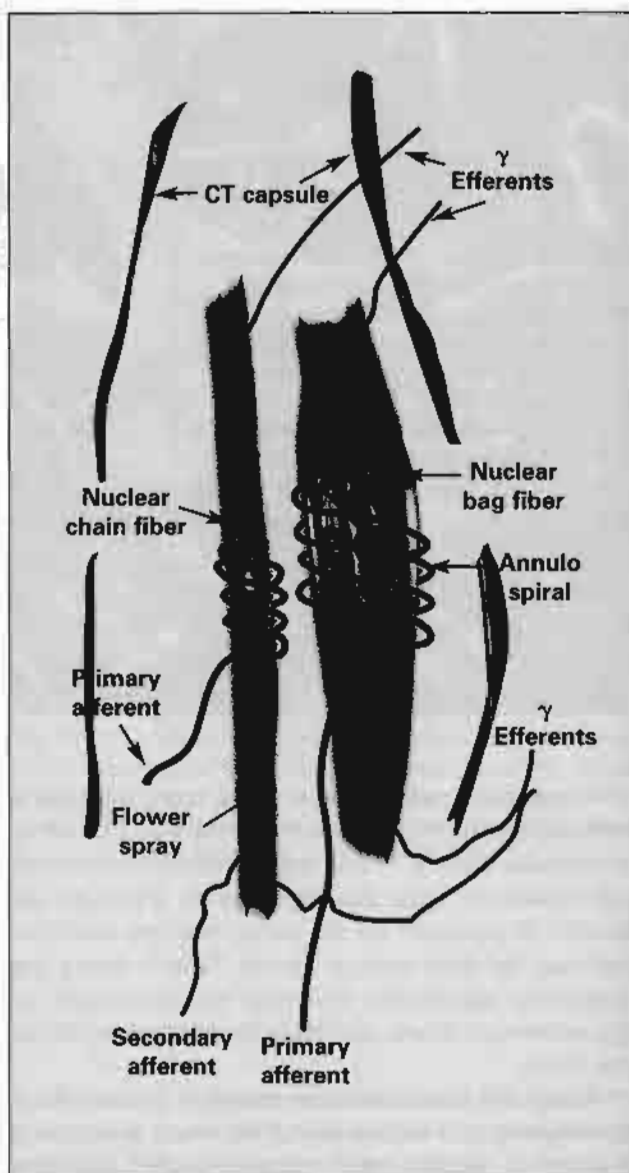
Muscle spindles contain nuclear chain and nuclear bag fibers. Each fiber is innervated by branches of primary and secondary afferent and γ -efferent nerves. (CT) Connective tissue.
